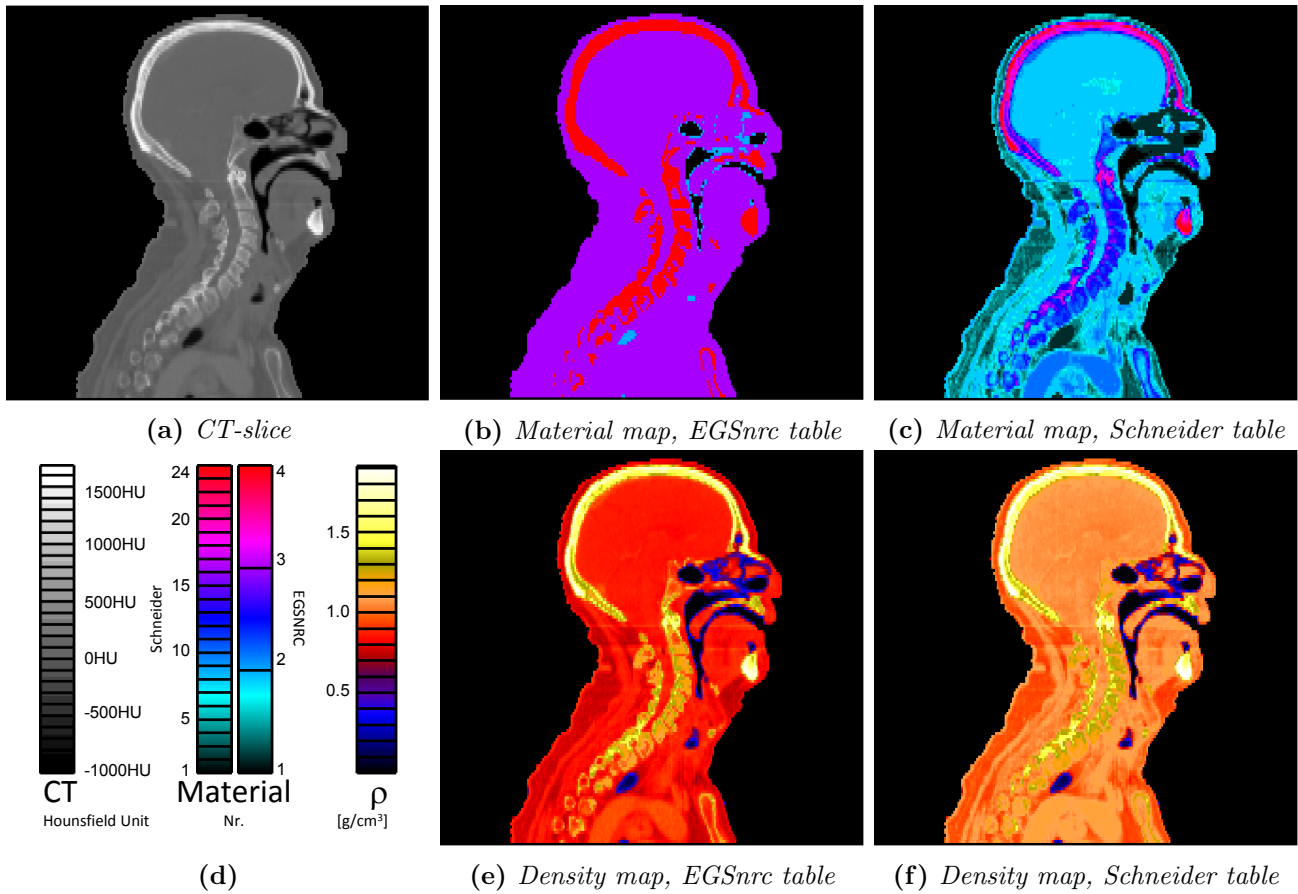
Sagittal slices of the CT cube and the material maps (top) and density maps (bottom) for the EGSnrc conversion table (left) and the Schneider conversion table (right)
